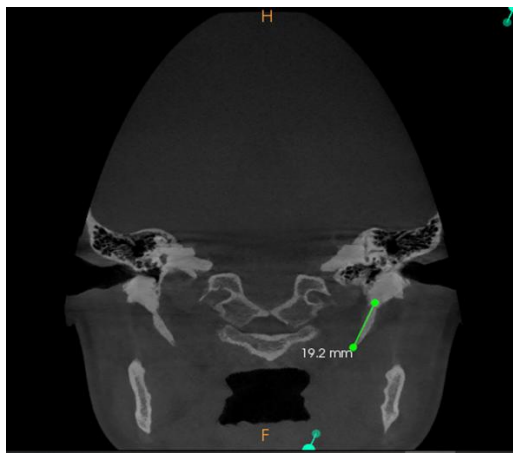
Styloid process measurement using multiplanar CT imaging.
